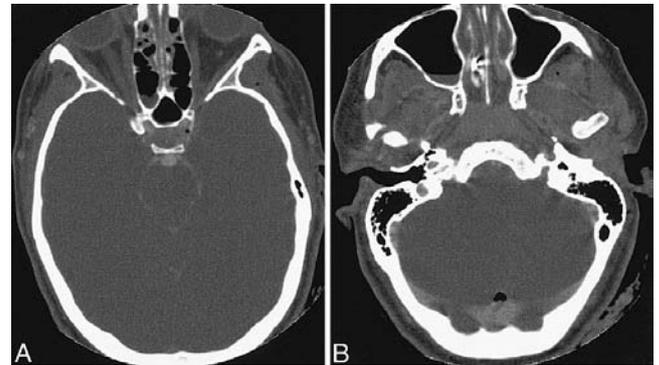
Axial infusion CT scans revealing a 5 × 8-mm basilar tip aneurysm (A) and an impressive heart-shaped air bubble in the region of the torcular herophili (B).
